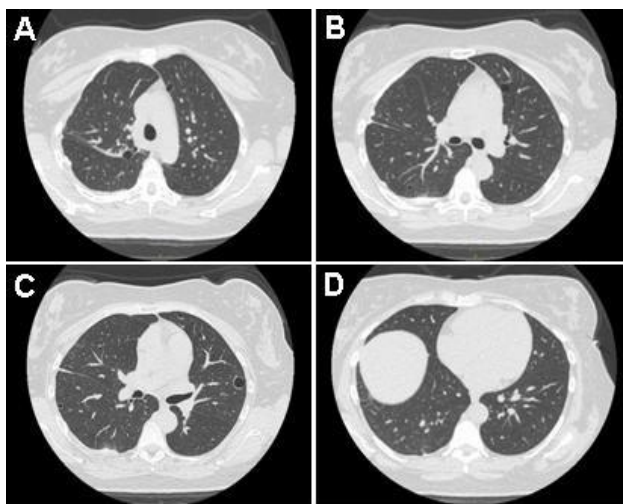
Repeat high resolution thoracic CT scan done in lung windows done in December 2020.
